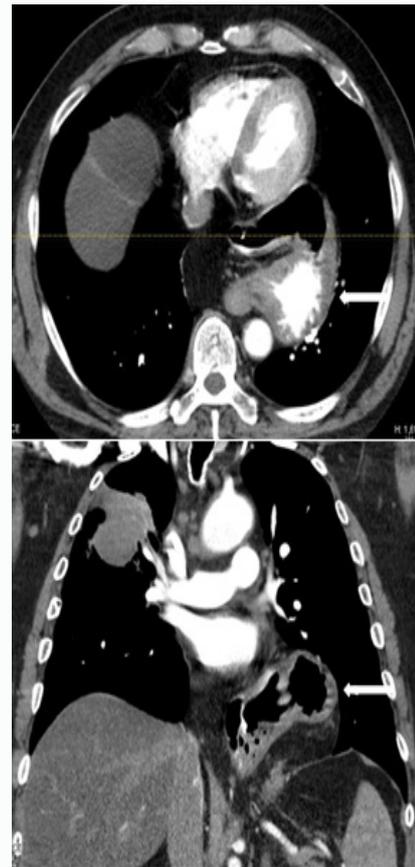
Axial and coronal images from preoperative CT scan showing the paraesophageal hiatal hernia (arrows).
